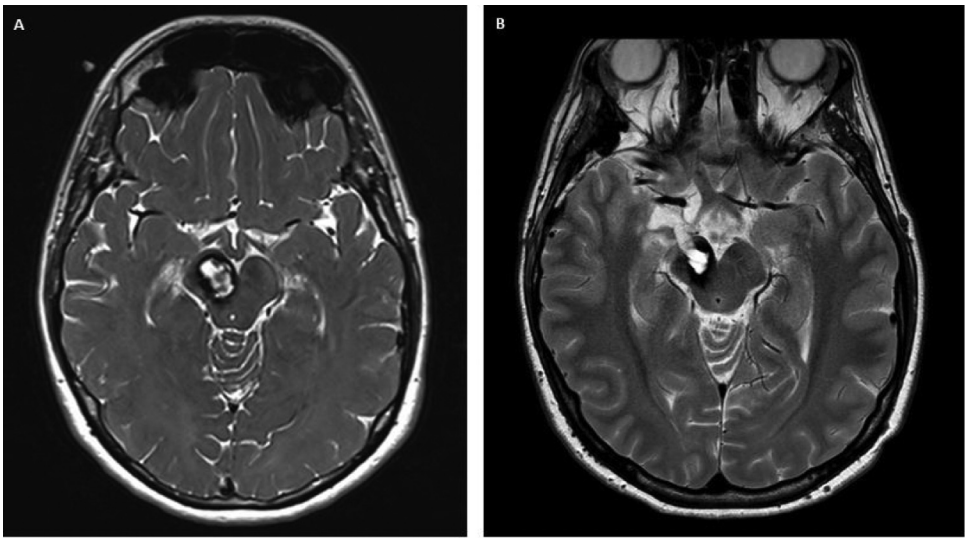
Patient 11: A. Preoperative axial T2-weighted MR image showing a cavernoma in the right part of crux cerebri and midbrain tegmentum. B. Postoperative last FUP T2-weighted brain MRI showing GTR.
